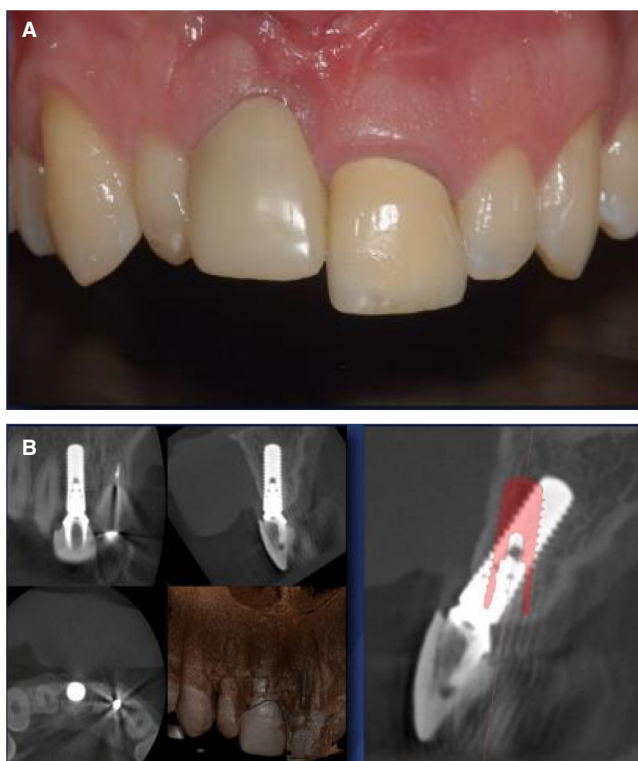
A, In this case, the implant in the maxillary right central incisor site is both positioned and inclined too far facially. B, In the sagittal view, an outline of an implant (red image) in the correct position has been overlaid on the CBCT scan of the implant. This highlights the combined facial position and facial inclination of the implant. CBCT, cone beam computed tomography
